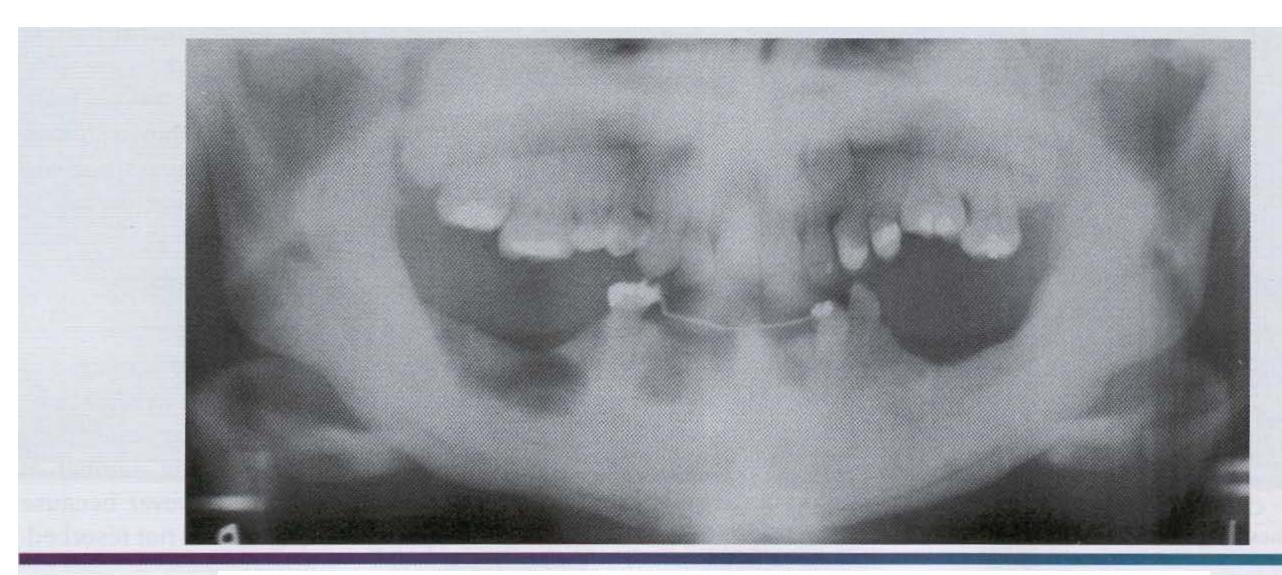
• Osteopetrosis. Extensive mandibular involvement is apparent in this radiograph of a 31-year-old woman. She had been diagnosed as having osteopetrosis as a child. There is a history of multiple fractures and osteomyelitis of the jaws. (Courtesy of Dr. Dan Sarasin.)
